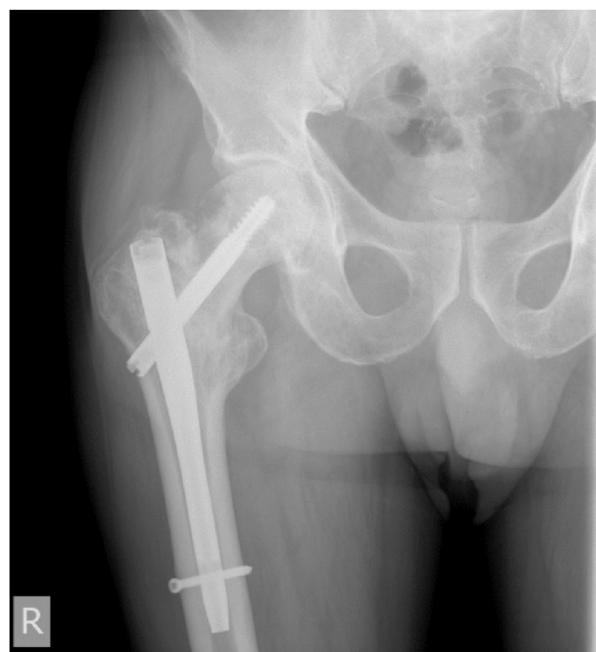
Antero-posterior radiograph at 6 months.
